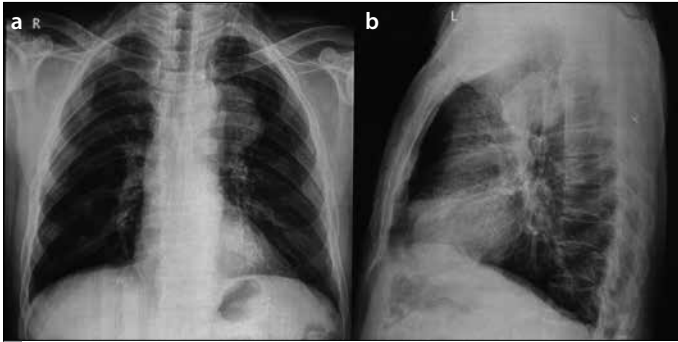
a, b. The progression of the lesion before posteroanterior chest radiography performed for control 8 months later (a). In the lateral radiography, a mass lesion localized in the upper mediastinum is seen (b)
